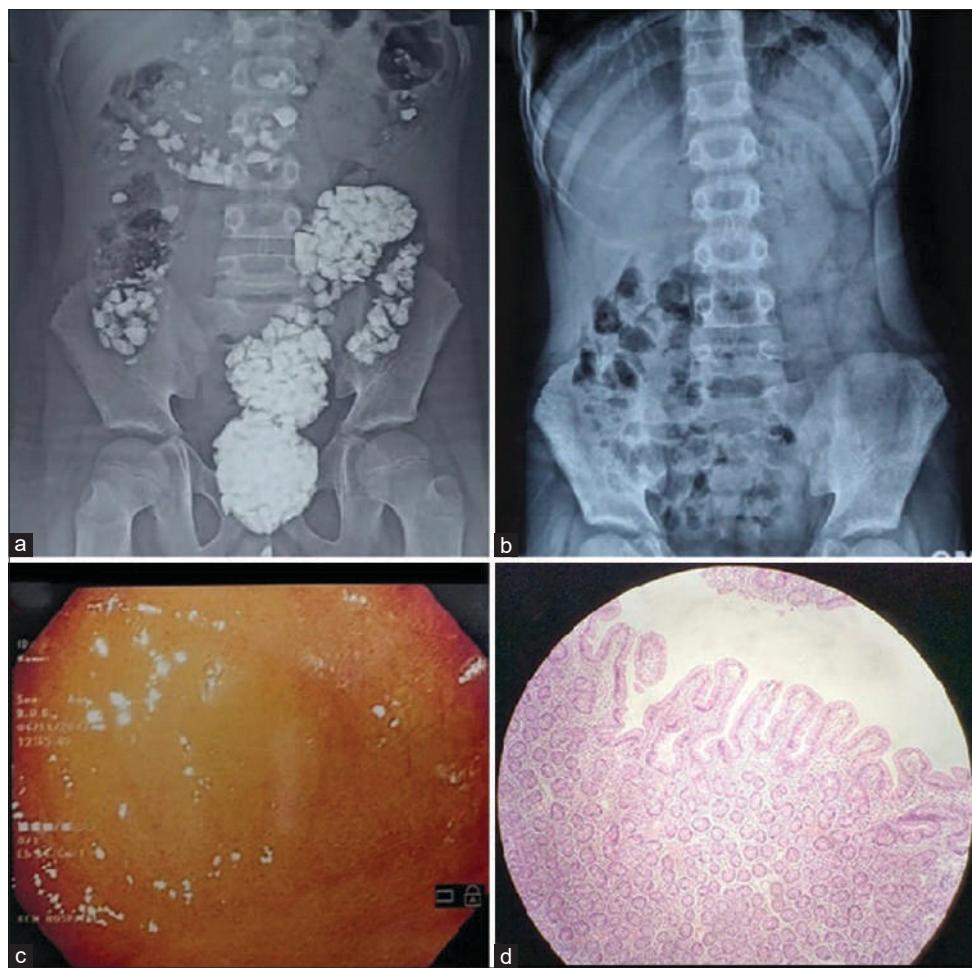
(a) Radiograph of the abdomen depicting extensively loaded colon due to lithophagia at presentation; (b) Clearance of stones after enemas and oral laxatives; (c) Upper gastrointestinal endoscopy picture showing decreased duodenal mucosal folds with extensive scalloping of mucosa, (d) Duodenal biopsy depicting increased intraepithelial lymphocytes, crypt hyperplasia and mild villous atrophy
